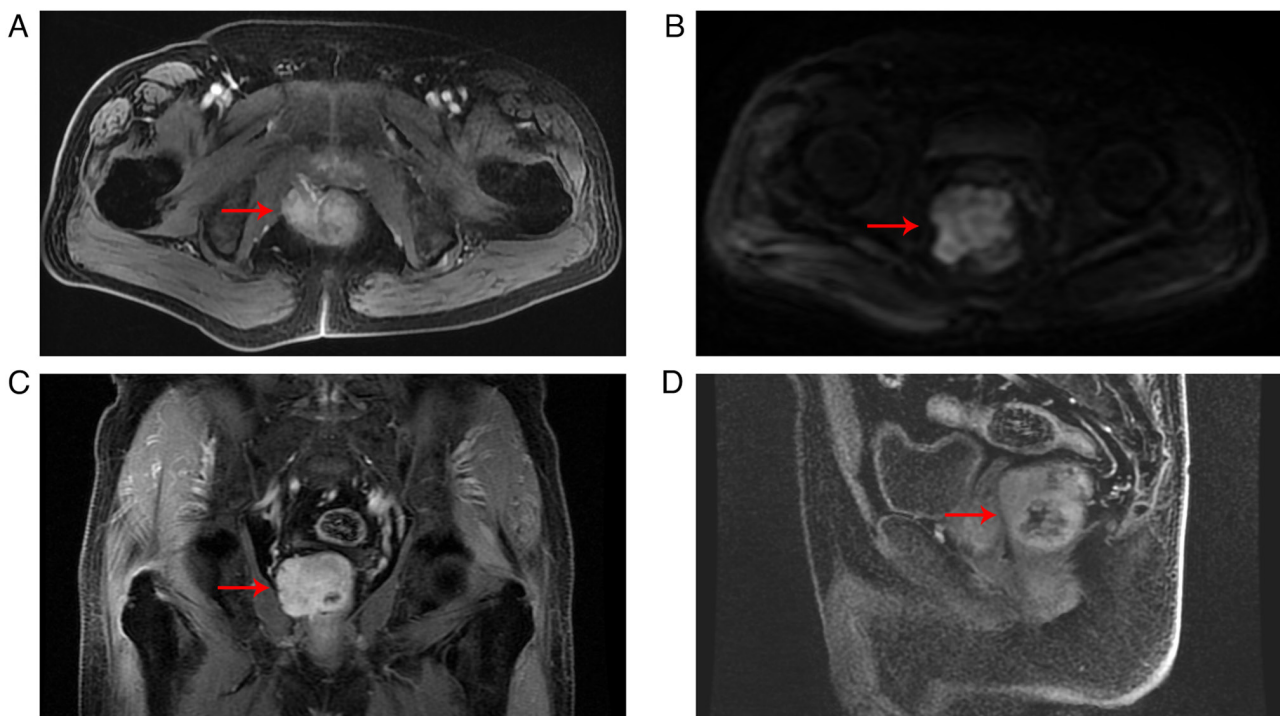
Contrast-enhanced MRI. (A) Enhanced MRI showing the main blood supply of the tumor. (B) Diffusion-weighted imaging of the tumor. (C) Enhanced MRI of the tumor in the coronal plane. (D) Enhanced MRI of the tumor in the sagittal plane. The red arrow points at tumor. MRI, magnetic resonance imaging.
